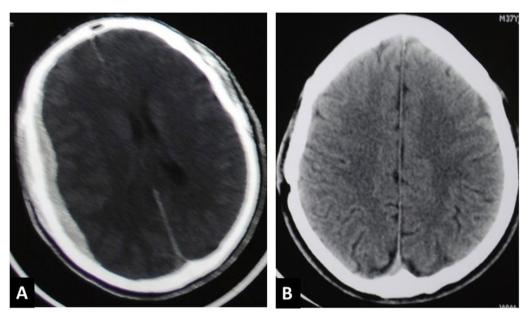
Pre (A) and Post (B) CT Scan of Brain. A—Right fronto-parietal acute subdural hematoma of about 10 mm in thickness, with effacement of ipsilateral ventricle and midline shift. B—Normal scan after craniotomy and evacuation of the hematoma
